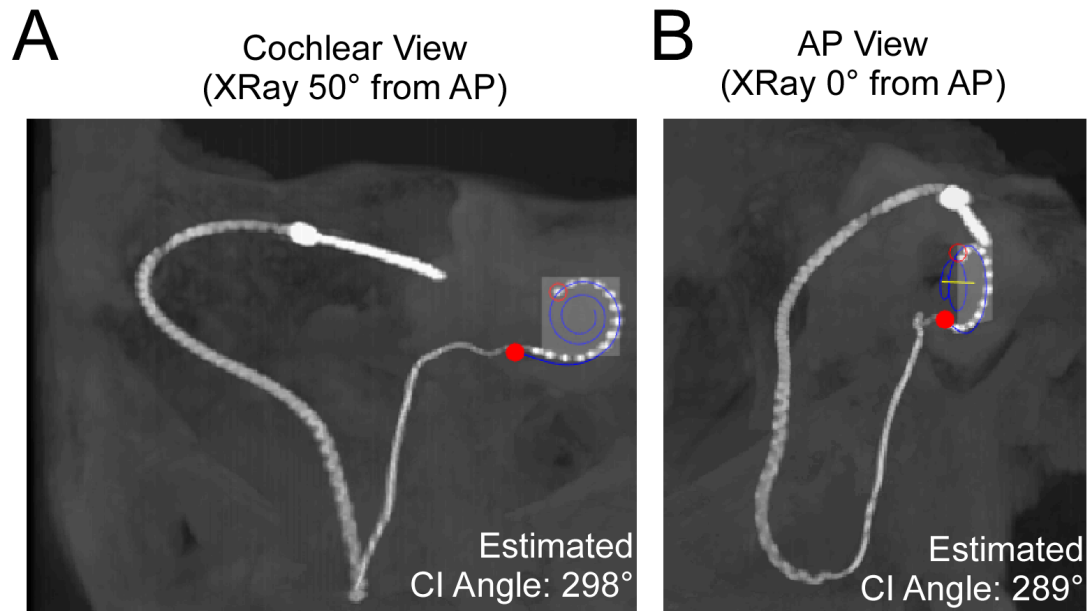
Implementation of 3D model on projected X-ray
